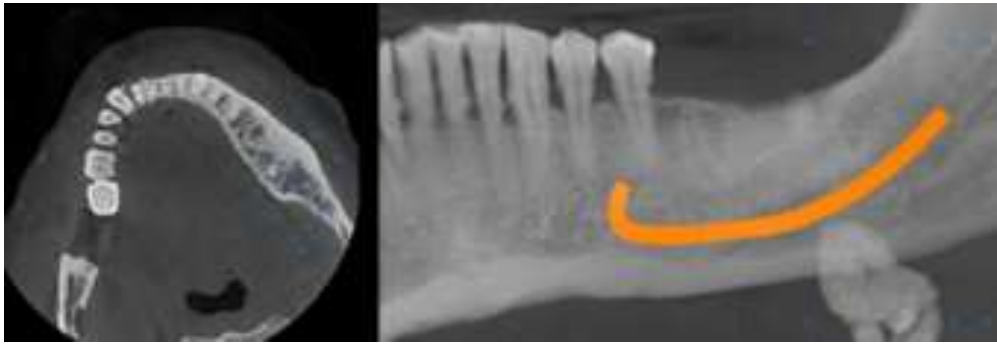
CBCT with respect to left mandible showing radiopacity in submandibular region.
